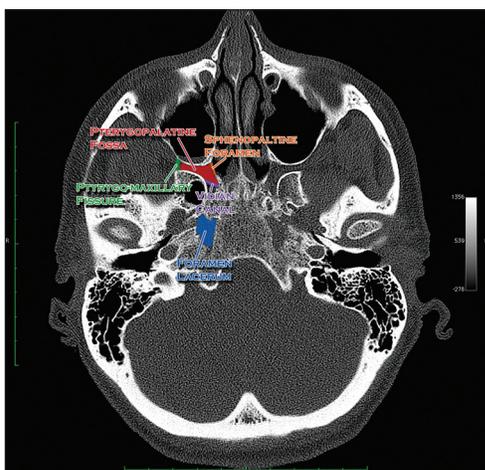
CT scan (bone window) axial section through the medial portion of the pterygopalatine fossa
